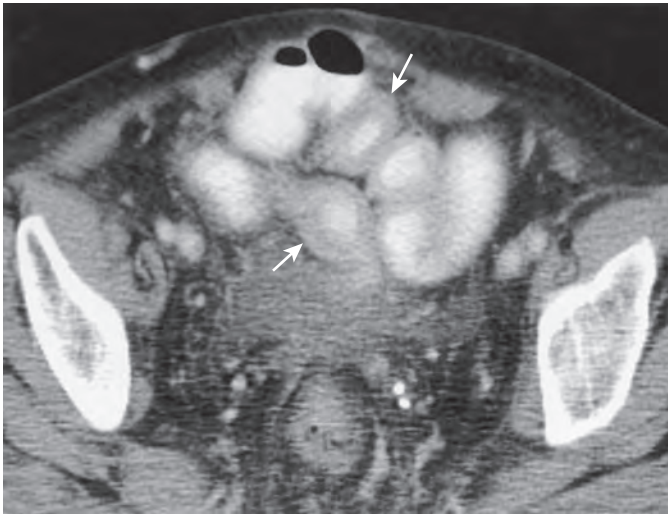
5-FUDR chemotoxicity. CT through the upper pelvis shows homogeneous thickening of the wall of several small bowel loops (arrows).
